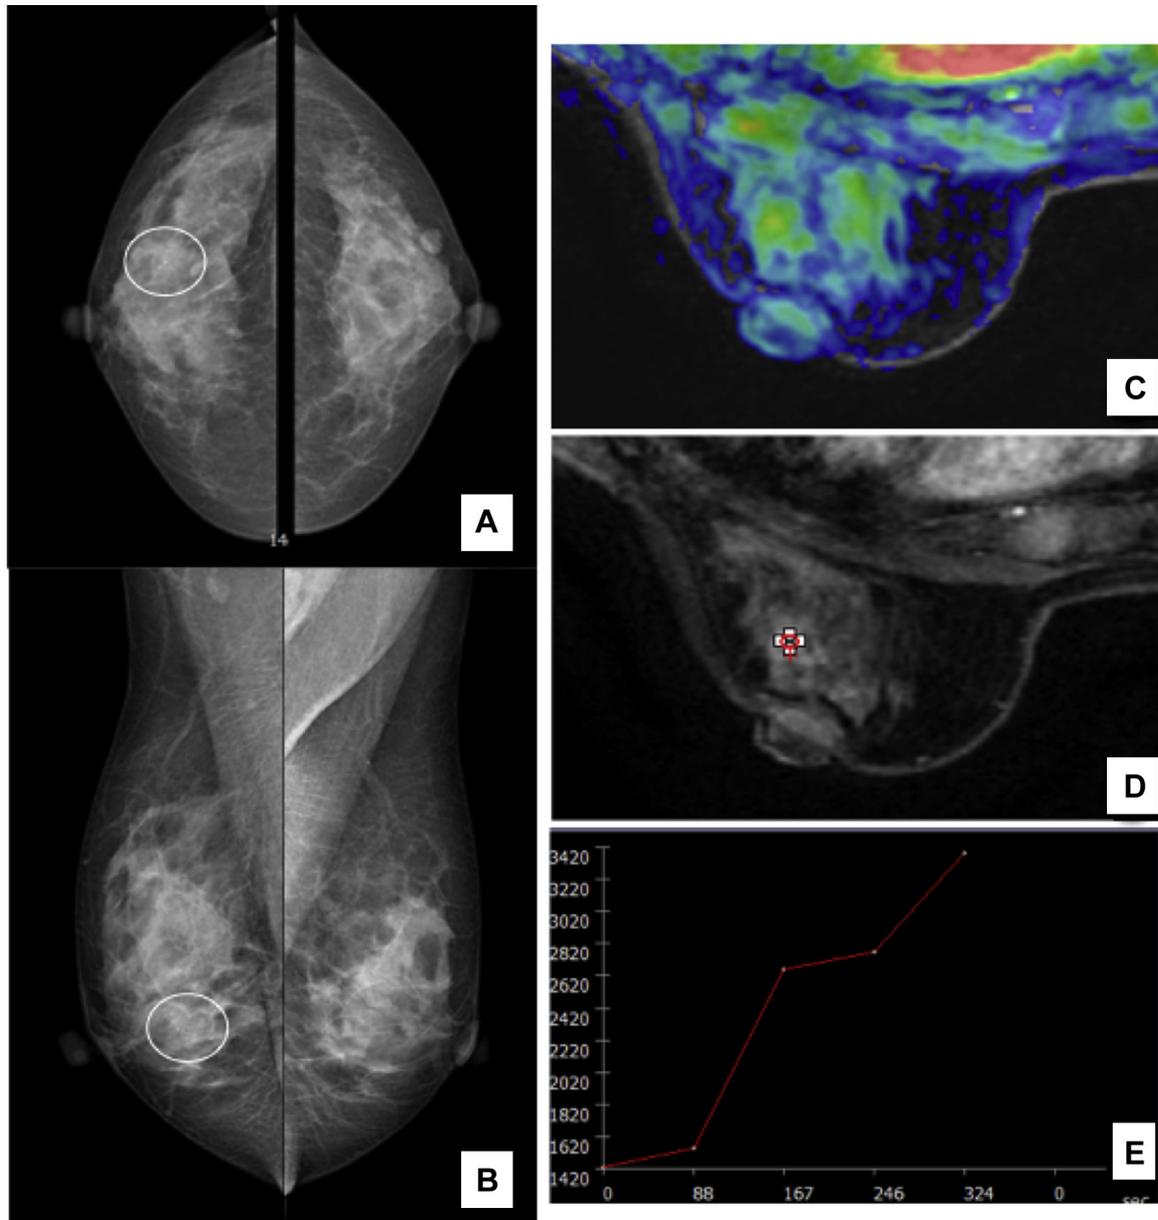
T.E., a 49-Year-old Woman With Family History of Breast Cancer and Identification of a Cluster of Punctate Microcalcifications in the External Peri-nipple Area of Right Breast at Screening Mammogram (A and B). The Patient Underwent Core Needle Biopsy With B3 Result (Atypical Ductal Hyperplasia). A Magnetic Resonance Imaging Examination Was Performed With Evidence of a Small Linear Area of Contrast Enhancement at T1-weighted Fat-suppressed 3D Gradient-echo With Blurred Edges (C and D) and Curve SI/T Type I (E). Grade 3 Ductal Invasive Carcinoma (Estrogen Receptor, 90%; Progesterone Receptor, 70%; Ki67, 50%; Human Epidermal Growth Factor Receptor 2, 2+) Was Found at Definitive Surgery
